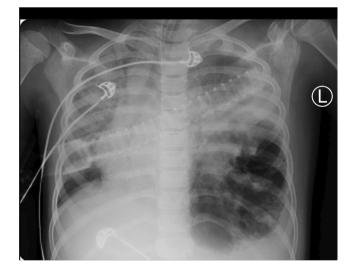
Bilateral parenchymal lung involvement, bilateral pleural effusion, left lung lower lobe consolidation, and collapse were observed in the patient's initial chest X-ray.
